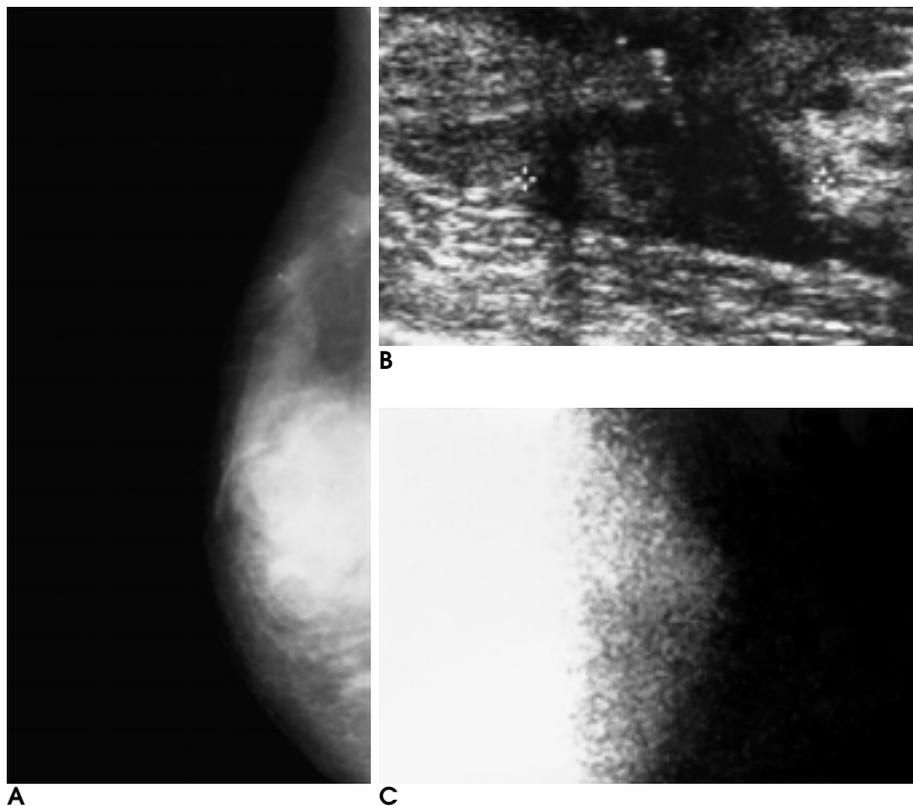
Invasive ductal carcinoma in 29-year-old woman interpreted as a malignancy on ultrasonography and mammography, but as a benign on ^{99m}Tc-MIBI scintimammography.
